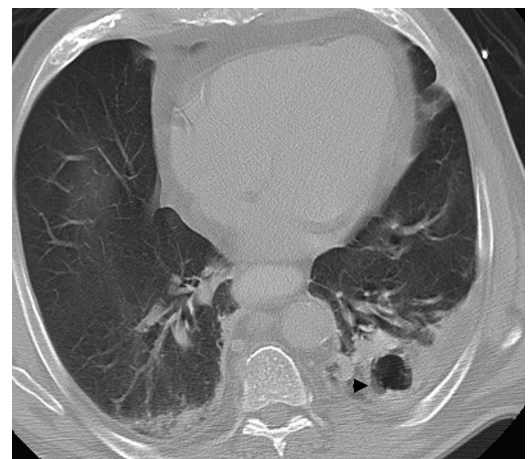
Axial CT image displayed in lung window settings reveals a parenchymatous opacity at the left base with a cavity (arrowhead), resembling a necrotising pneumonia or a necrotic tumour.
